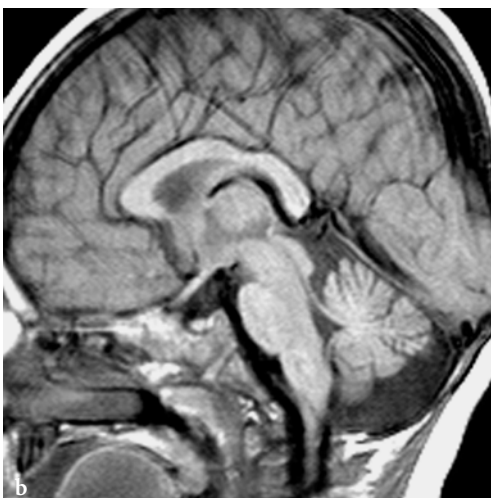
Progressive atrophy of the cerebellar vermis on sagittal T1-weighted spin-echo images in a male patient with 3-methylglutaconic aciduria. a The examination at the age of 1 year shows a normal cerebellum. b At the age of 18 months, the follow-up study reveals definite atrophy of the cerebellar vermis. c The follow-up study at the age of 2 years shows further progression of cerebellar atrophy
